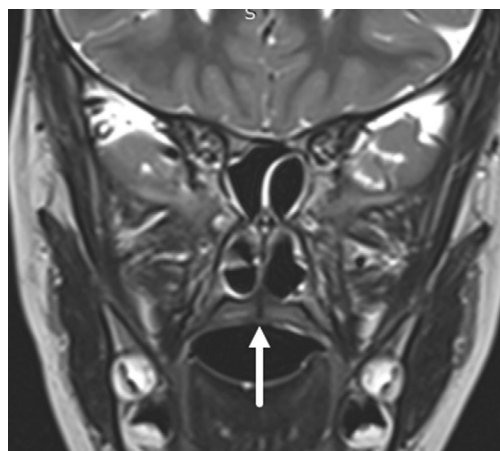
Hypointense linear structure along the midline of the palate (arrow) in T2 view in a magnetic resonance image.
